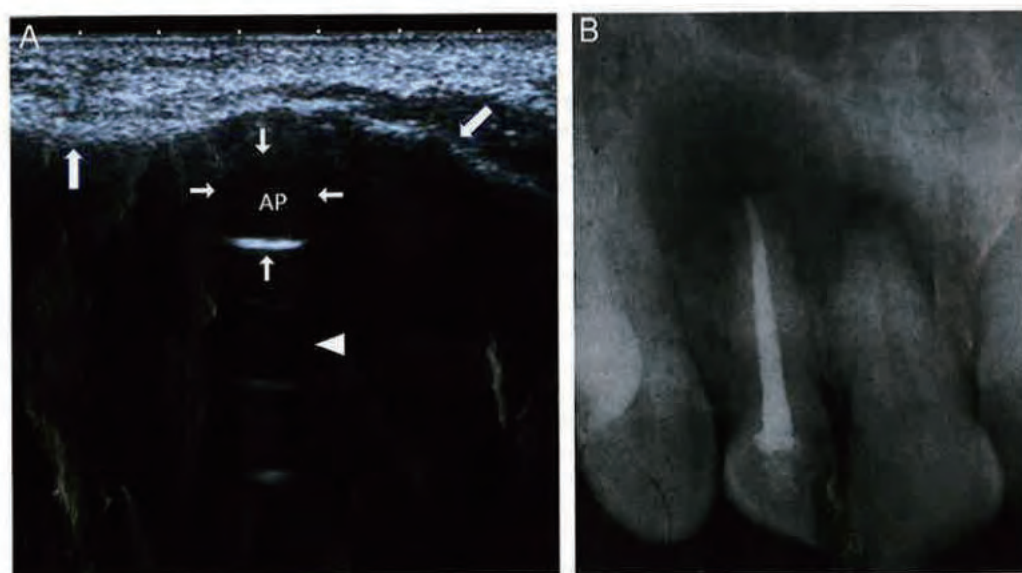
(A) An echographic image of AP showing an intact cortical bone plate (arrows) and the posterior acoustic reinforcement (arrowhead). (B) A periapical radiograph depicting the same lesion (tooth #7).
